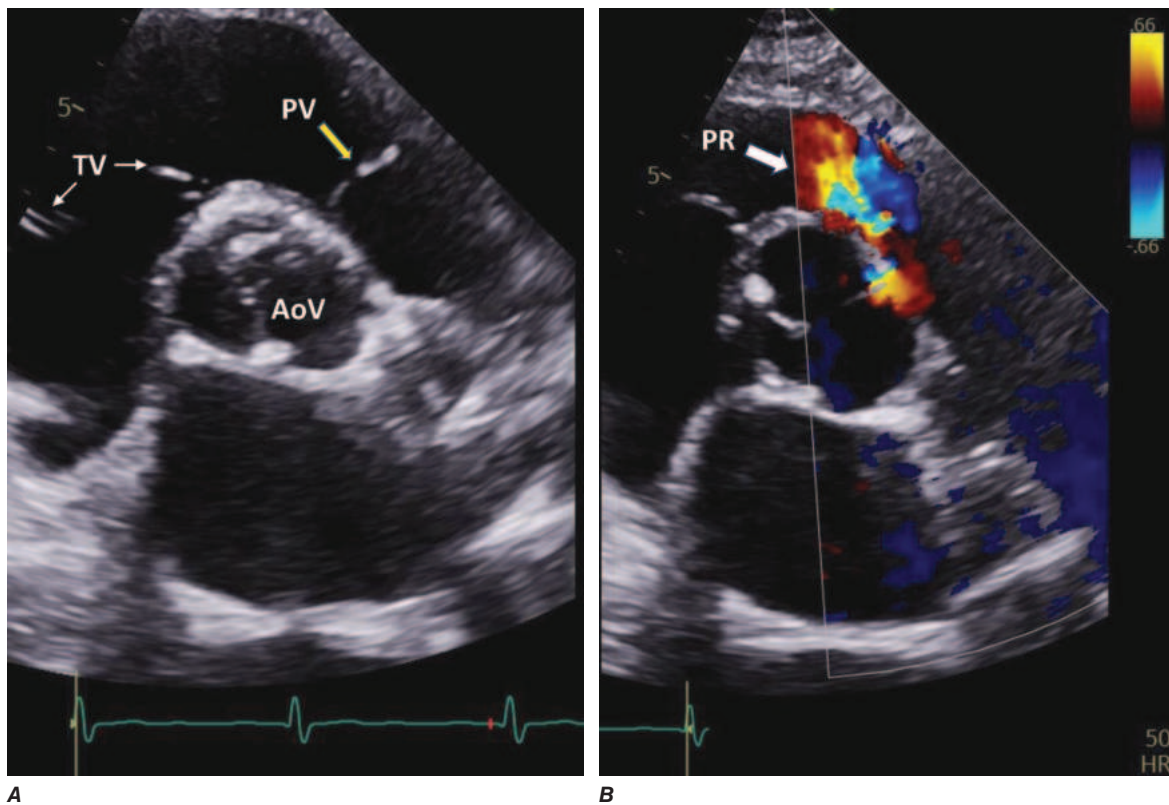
Pulmonic regurgitation. A. Transthoracic short axis window at the level of the aortic valve (AoV). The pulmonic valve (PV) is shown with the yellow arrow. Tricuspid valve (TV) leaflets are partially visualized (white arrows). B. Color flow Doppler image shows moderate pulmonic regurgitation (PR, white arrow).
